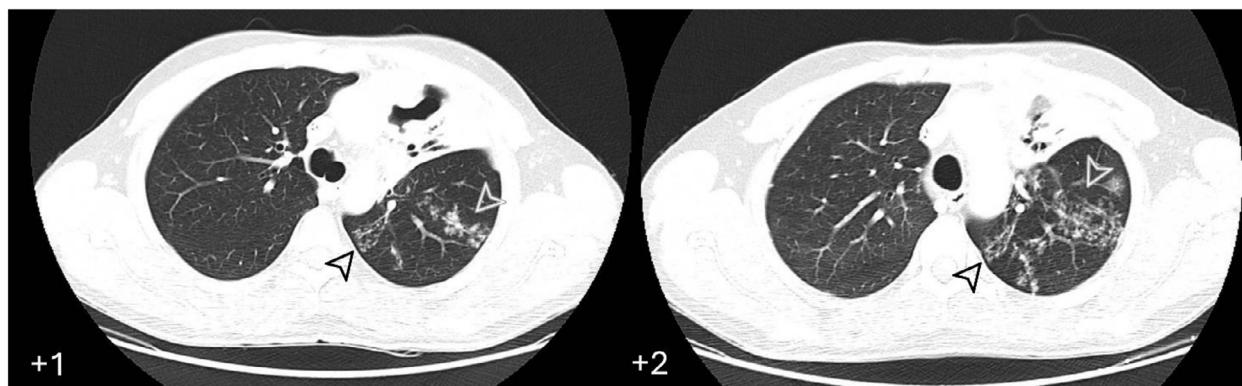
At 1 (+1) and 2 (+2) months after COVID-19 diagnosis (concomitant with indication for CAR-T therapy, time 0), the CT scan did not show any typical signs of COVID-19 pneumonia. However, new lesions with a tree-in-bud shape (arrows), not present in previous scans, appeared and were confirmed at the following scan.
